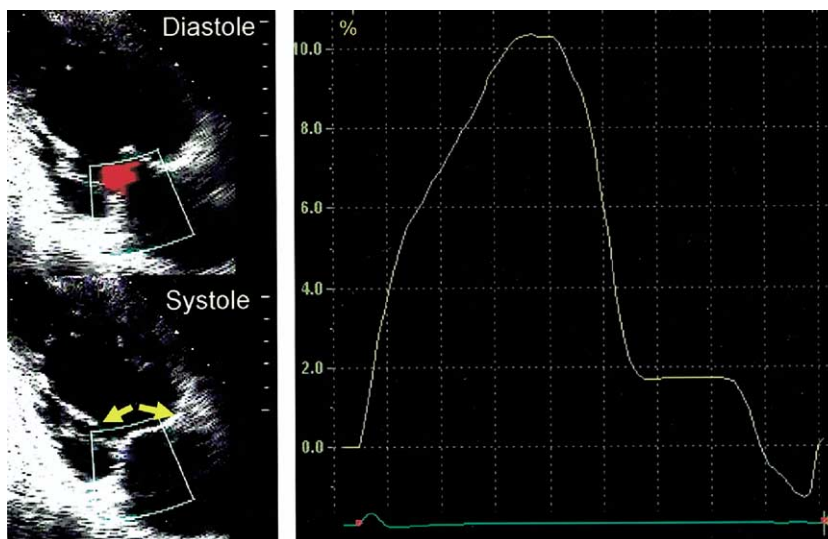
A patient with trace mitral regurgitation (MR) despite poor papillary muscle (PM) function shown by absent systolic PM thickening on two-dimensional echocardiography (left upper and lower panels) and systolic PM longitudinal elongation as assessed by strain imaging (right panel). The medial PM tethering distance (arrows) is normal and can explain the lack of significant MR.
